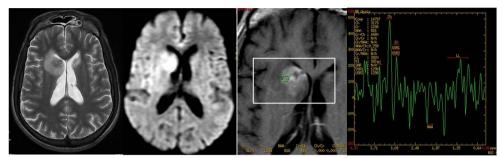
Case of 36 year male patient with PCNSL.T2 weighted axial(A)shows predominantly hypointense lesion in bilateral frontal regions in periventricular location,DWI image(B)shows diffusion restriction,post contrast T1 weighted Coronal image(C)shows solid heterogenous enhancement and MRS shows increased choline.
